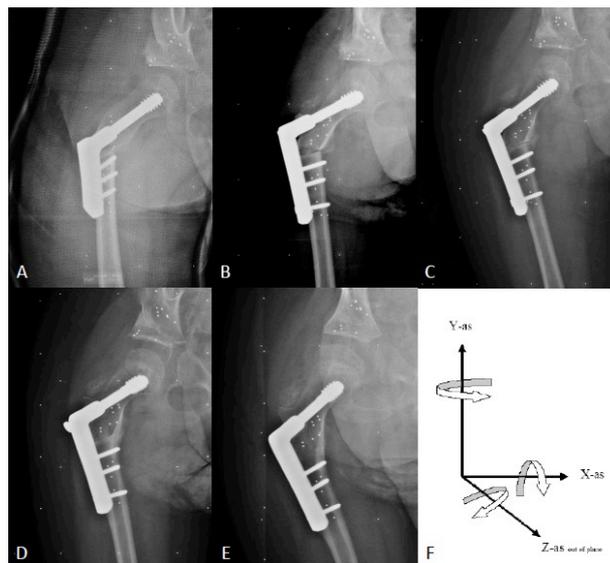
RSA radiographs at postoperative time 0 weeks (A), 5 weeks (B), 3 months (C), 6 months (D) and 12 months (E). In figure D and E the VDRO is considered radiographic stable. F: Shows the orientation of the 6 degrees of freedom with positive values of a right distal femur distal. Hence, translations x₊ = medial, y₊ = superior and z₊ = anterior and rotations Rx₊ = anterior tilt, Ry₊ = internal rotation and Rz₊ = varisation.
